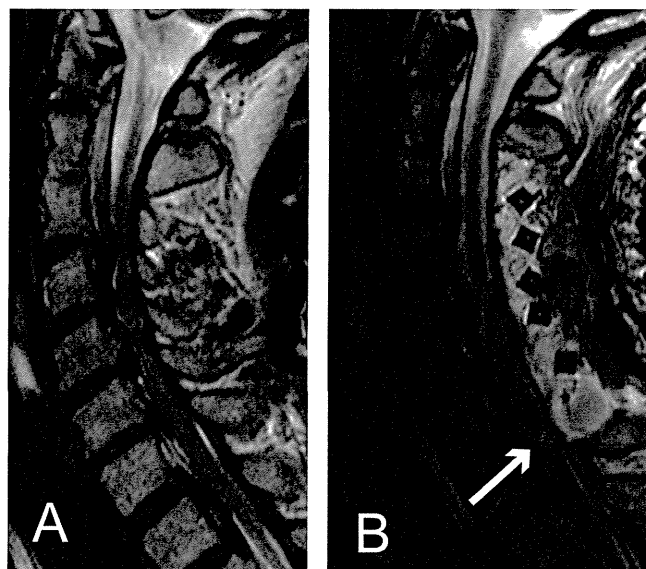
Newly developed high-intensity area between C7 and T1 on T2-weighted imaging (arrow). (A) Preoperative and (B) postoperative.
